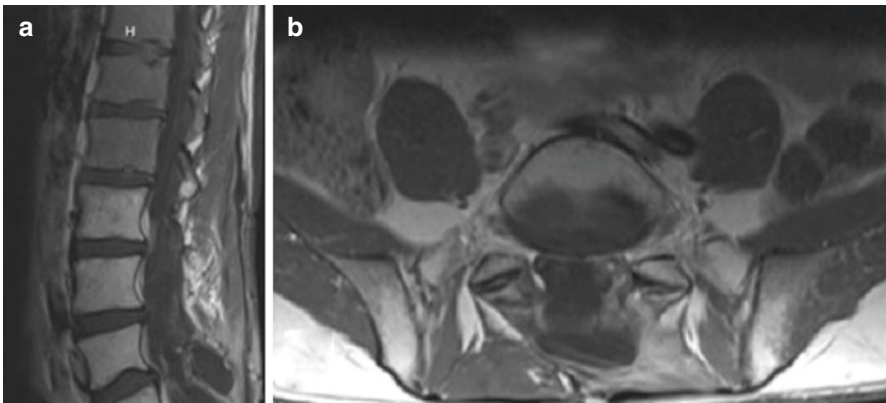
Sagittal (a) and axial (b) MRI showing no tumor recurrence at 6-month follow-up
